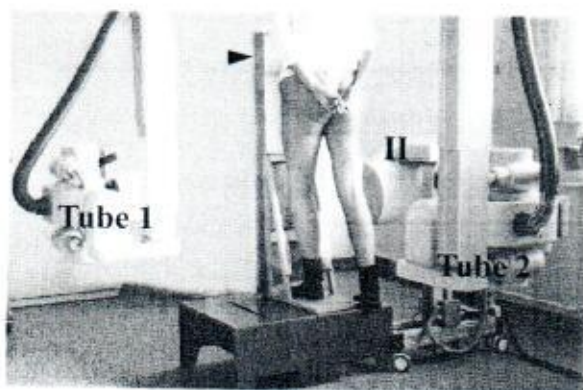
Biplane radiography of the knee supported by the device. A true lateral position of the femoral condyles is obtained at fluoroscopy using tube 1 and the image intensifier (II). A true anteroposterior view is obtained perpendicularly from tube 2. The film is placed in a cassette holder (arrowhead) also used for whole limb radiography
